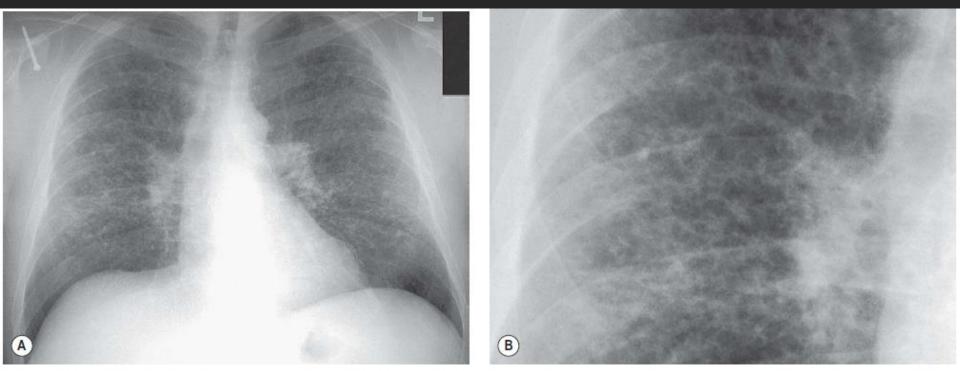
A, Chest radiograph with B, magnified view shows characteristic features of pulmonary Langerhans cell histiocytosis. There is a diffuse parenchymal abnormality due to cysts and nodules, with upper and mid-lung predominance, and sparing of costophrenic sulci. Lung volumes are preserved. Enlargement of central pulmonary arteries suggests pulmonary arterial hypertension.
